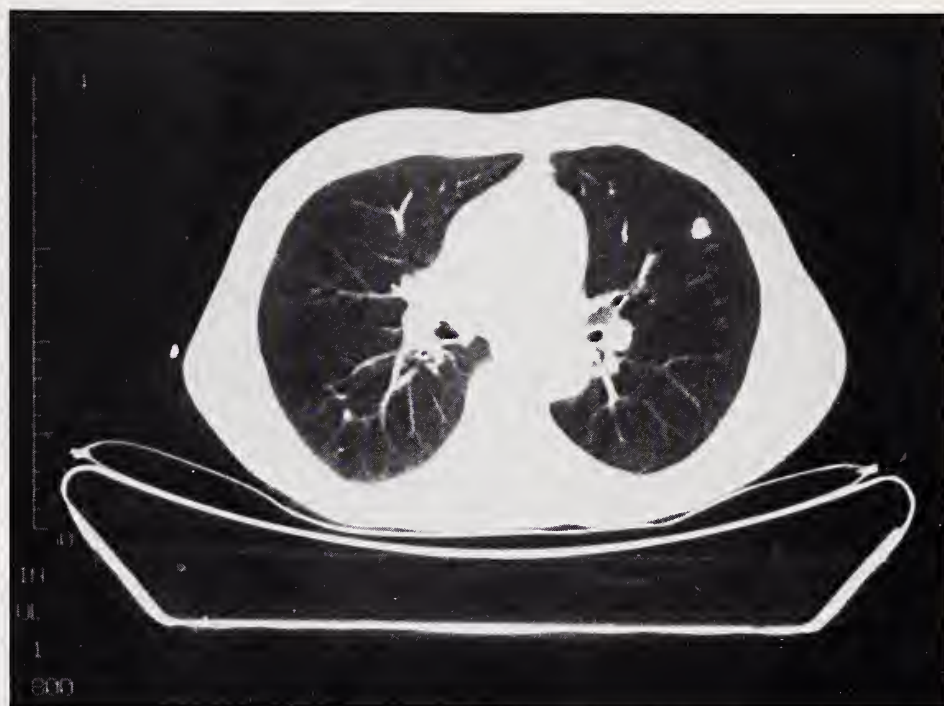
CT scan demonstrating a 1cm nodule in the lingula segment of the left upper lobe.
